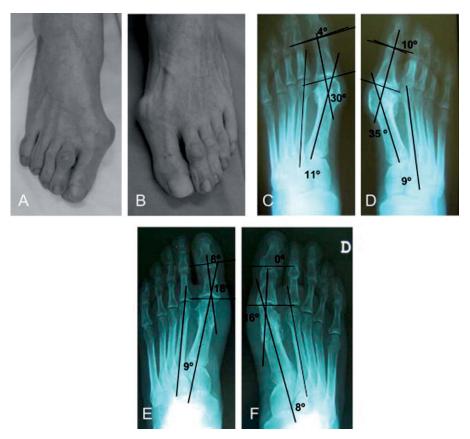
72-year old woman, bilateral. Macroscopic view and preoperative radiographic study. A) Right foot: hallux rigidus. By C) Left foot: hallux valgus. D) Right foot: hallux rigidus. E) 2 years' follow-up. Note incipient development of hallux rigidus in the left foot. F) 2 years' follow-up. American Orthopaedic Foot and Ankle Society Scores: 90 points for the right foot: and 72 points for the left foot. Subjective evaluation for the right foot: excellent; left foot: acceptable.
